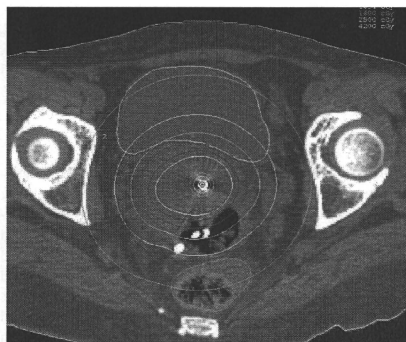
Dose distributions of intracavitary brachytherapy projected onto the axial CT image.
